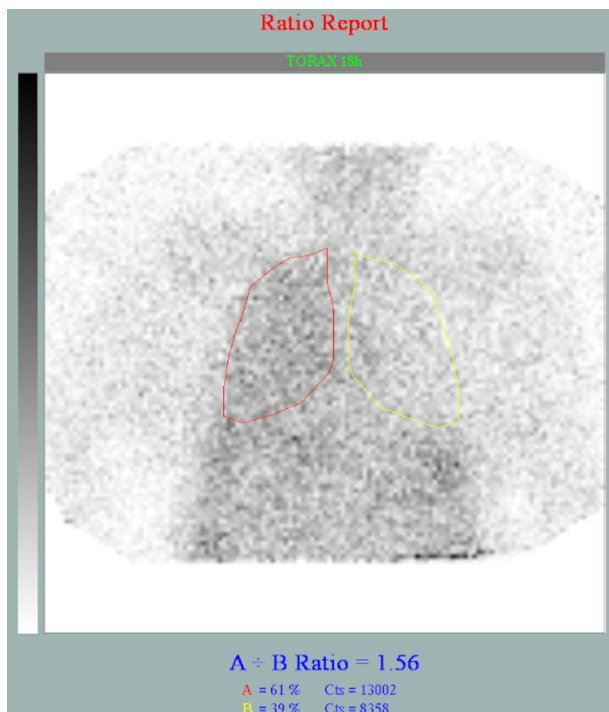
Peritoneal scintigraphy with infusion of ^{99m}Tc -DTPA into the pleural fluid. After 18 h in situ (late phase), it shows a pattern of diffuse increased uptake of the radiotracer in the right hemithorax.
